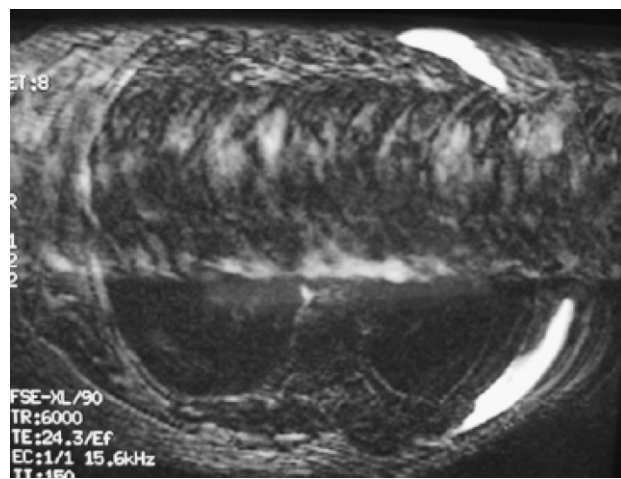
MRI scan of the thorax at a level more distal than that in Fig. 1 showing the silicone extending to the lateral borders of erector spinae.
